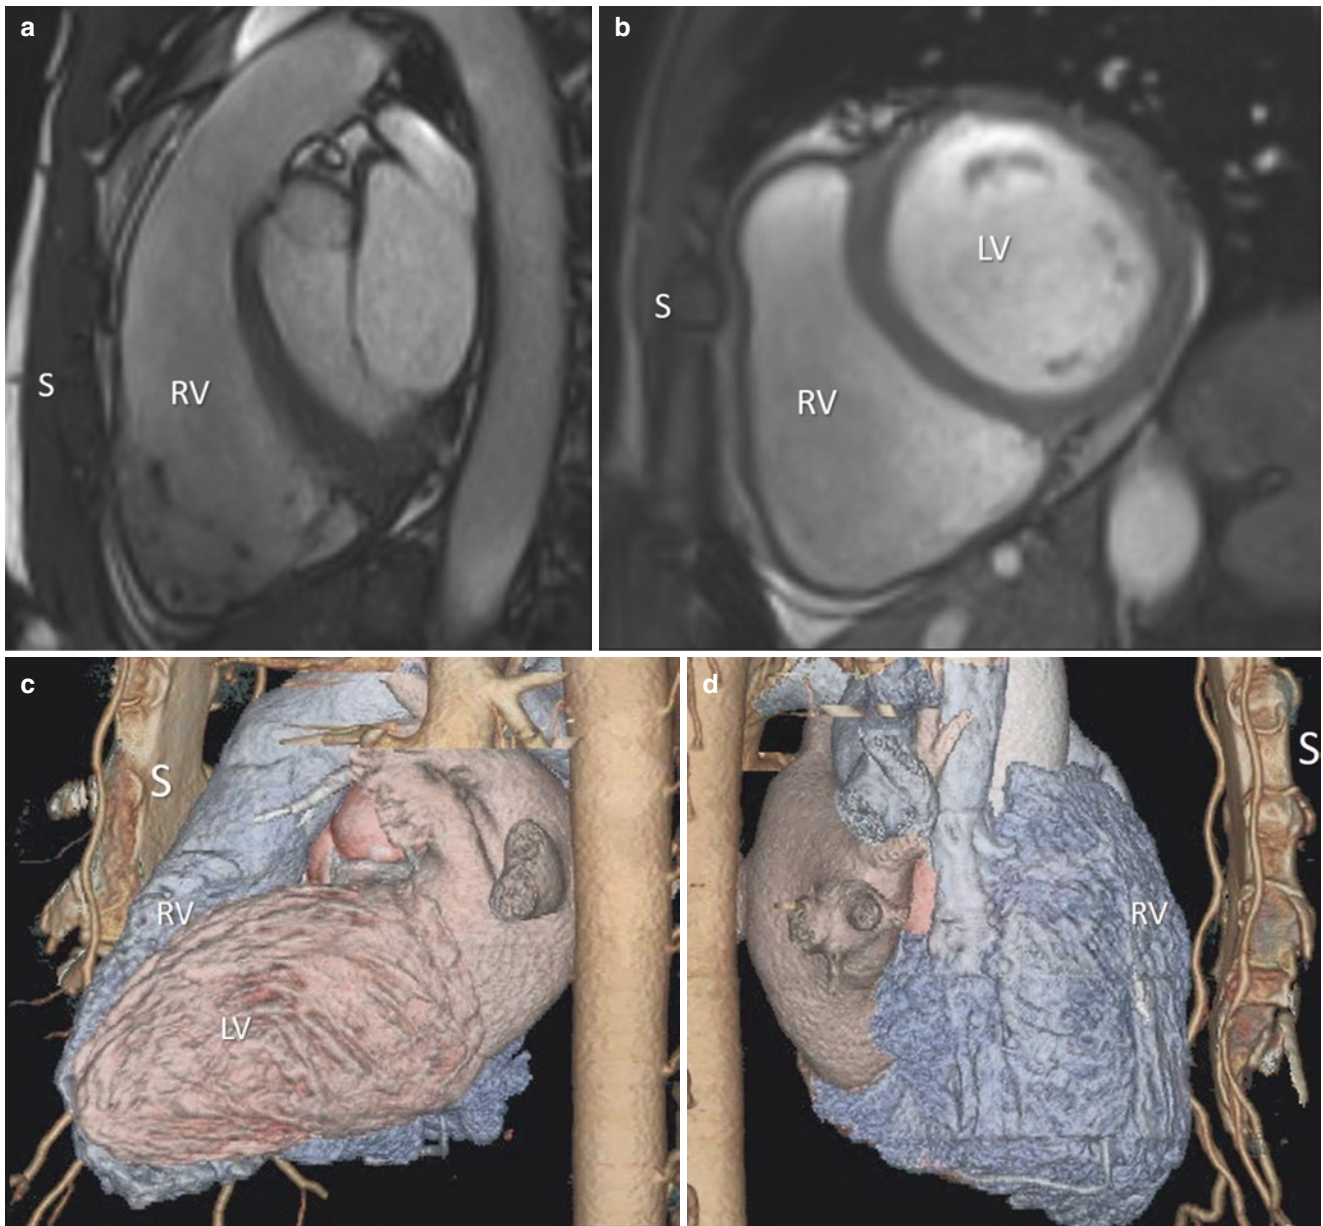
CMR in longitudinal (a) and cross-sectional (b) view and CT electronic casts (c and d) in two different perspectives showing the right ventricle (RV) anterior to left ventricle (LV) located just behind the sternum (S)
